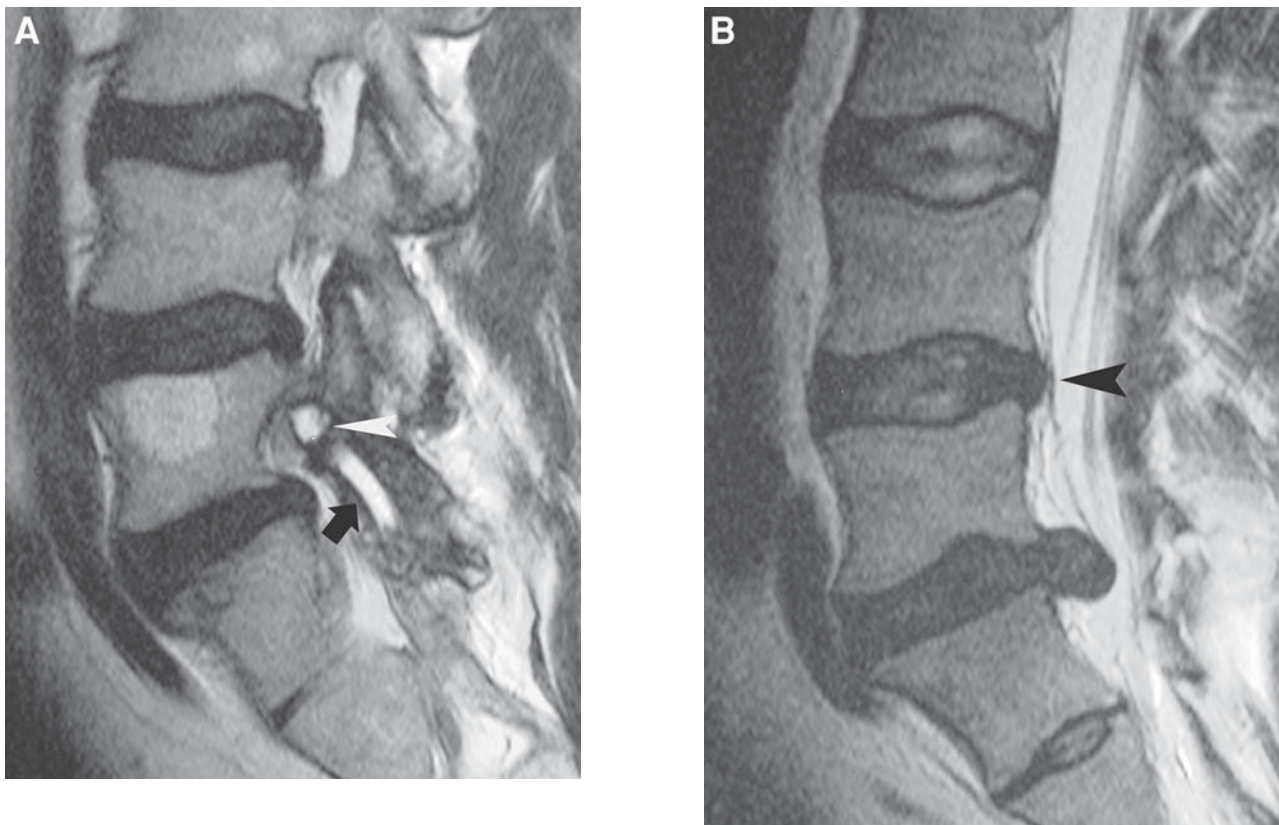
(A) Sagittal T2 MRI showing fluid in the facet joint (*dark arrow*) and a synovial cyst (*white arrowhead*). (B) Sagittal T2 MRI showing a large disc herniation at L5–S1 and disc desiccation and a disc bulge at L4–5 (*arrowhead*). This represents some of many potential pain generators in the spine.
